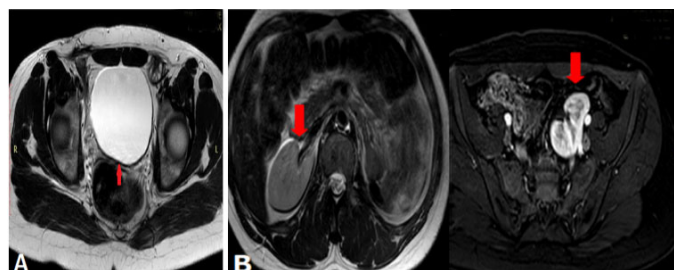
Pelvic MRI T2-weighted (A) axial plane showing uterine agenesis, without the image of the uterus between bladder and rectum (arrow), in the abdomen in (B) presence only of the right kidney (arrow), and T1 fat sat gadolinium the left pelvic kidney (arrow).
